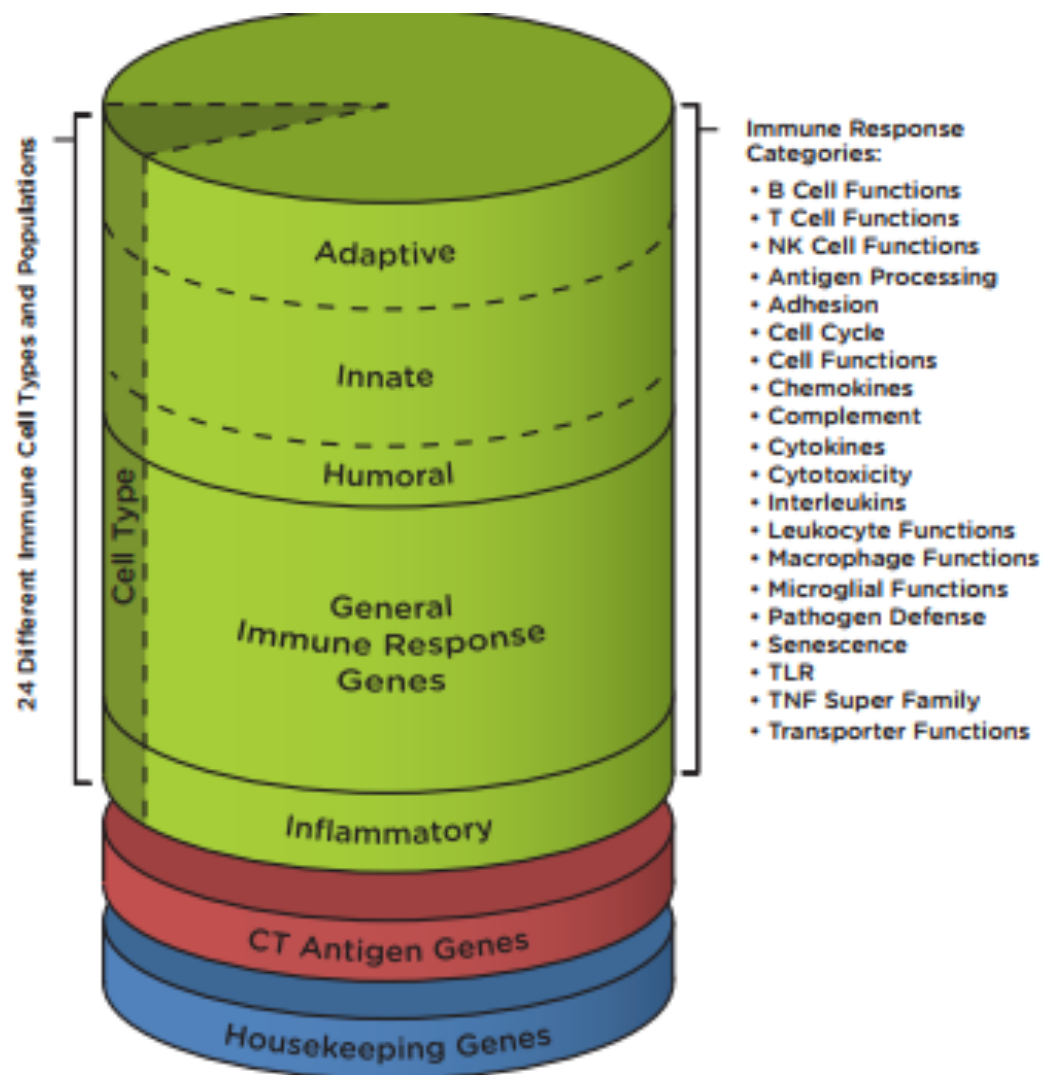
Distribution of genes included in the PanCancer Immune Profiling Panel, including genes for identifying Immune Cells (dark green), Immune Response genes (green), CT Antigens (red) and Housekeeping genes (blue). Biological process categories comprising the Immune Response genes are indicated on the right.
